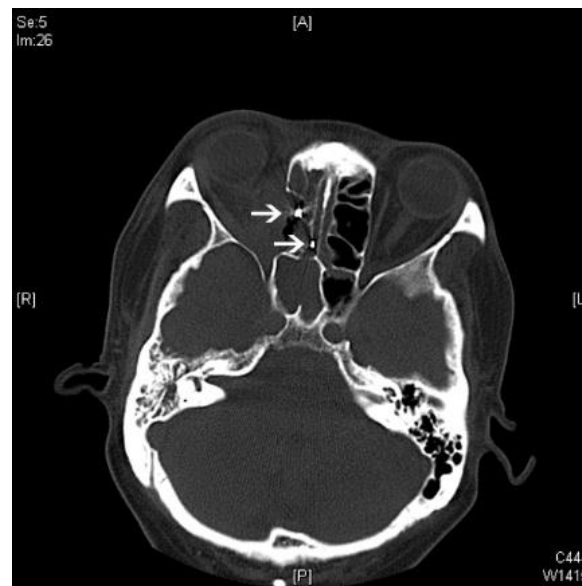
Computed tomography scan of the head in transverse cut
